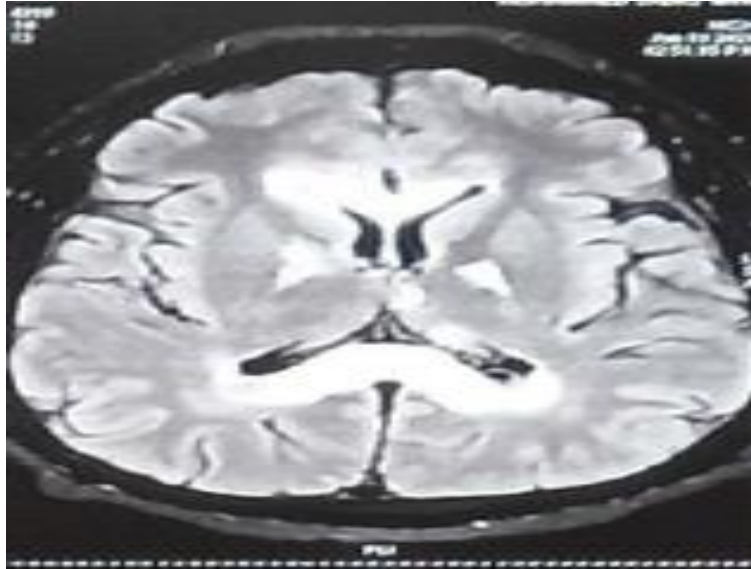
MRI showing extensive corpus callosal hyperintensity
